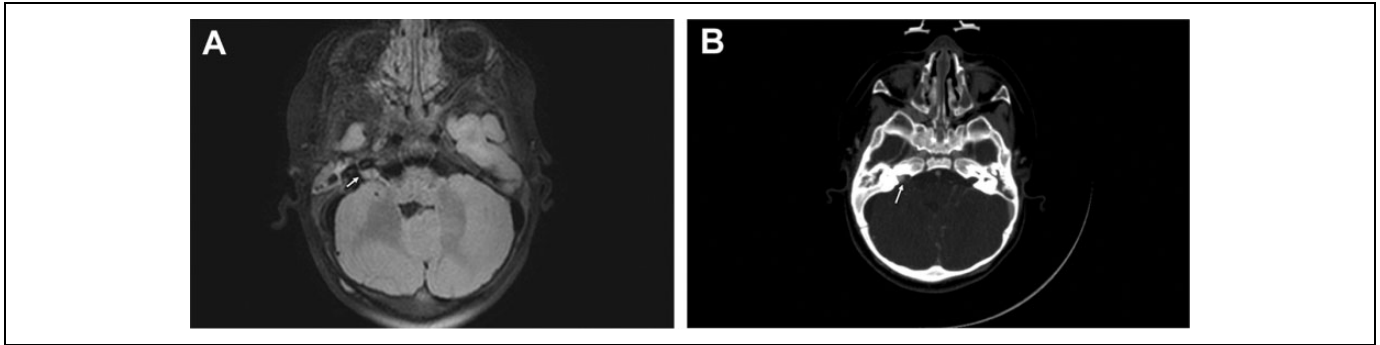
2012 Axial T2 Flair MR image (A) and axial CT scan with contrast (B) showing an enhancing mass within the right internal auditory canal consistent with hemangioma. CT indicates computed tomography; MR, magnetic resonance.
